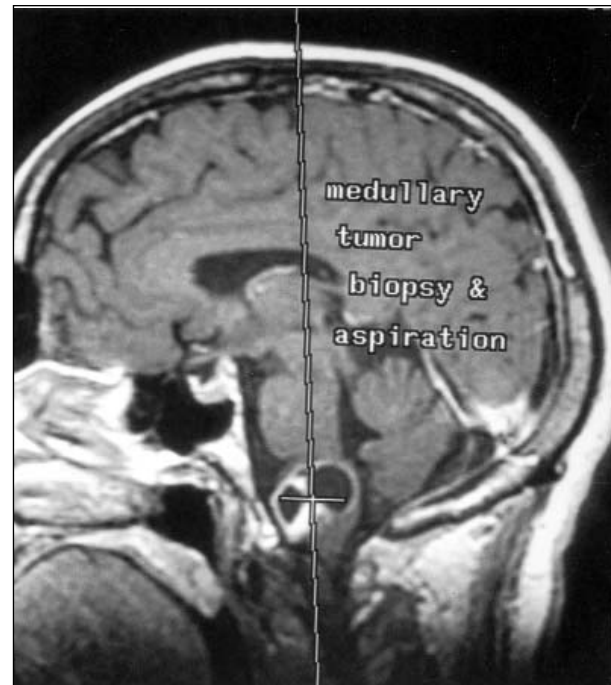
B: Sagittal T1-weighted contrast enhanced MR image showing the trajectory of planned stereotactic aspiration of cystic medullary tumor.
